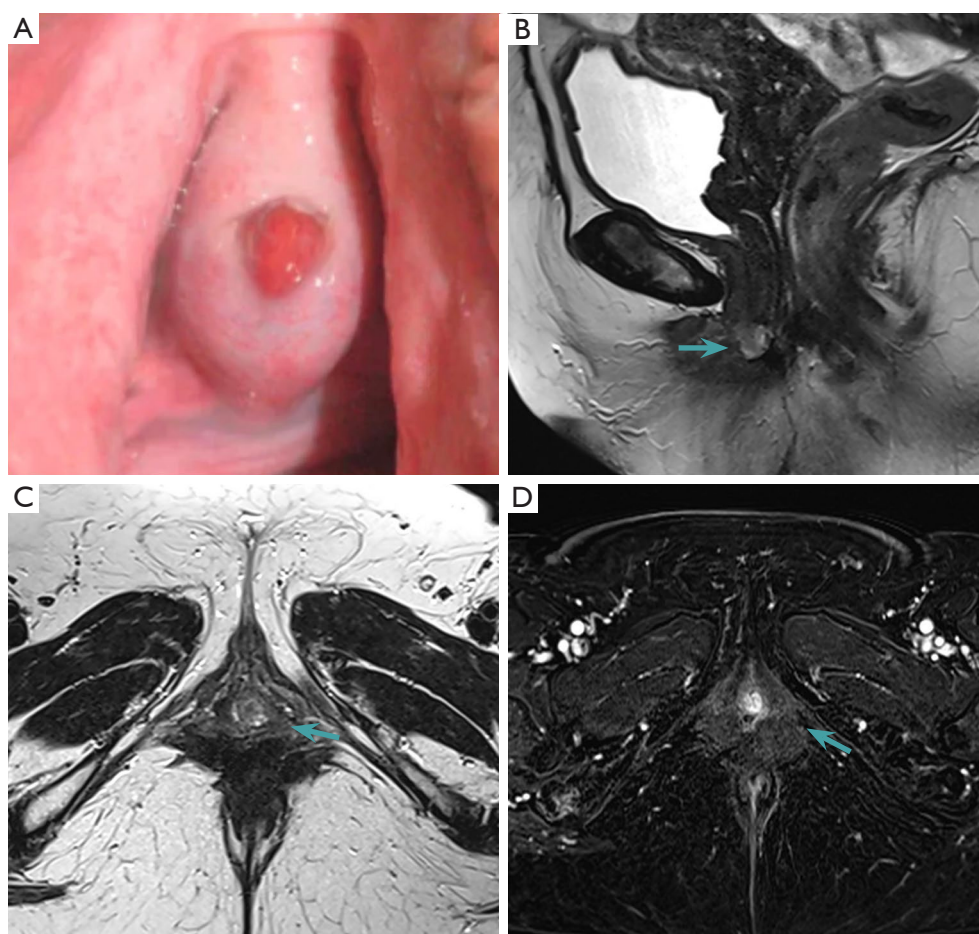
Paraurethral caruncle. Preoperative photo (A) and MRI with VSD show a nodular lesion (green arrows) below the perineal membrane, with mild hyperintensity on T2 (B,C) and peripheral enhancement on post-contrast images (D). MRI, magnetic resonance imaging; VSD, vaginal saline distension.
